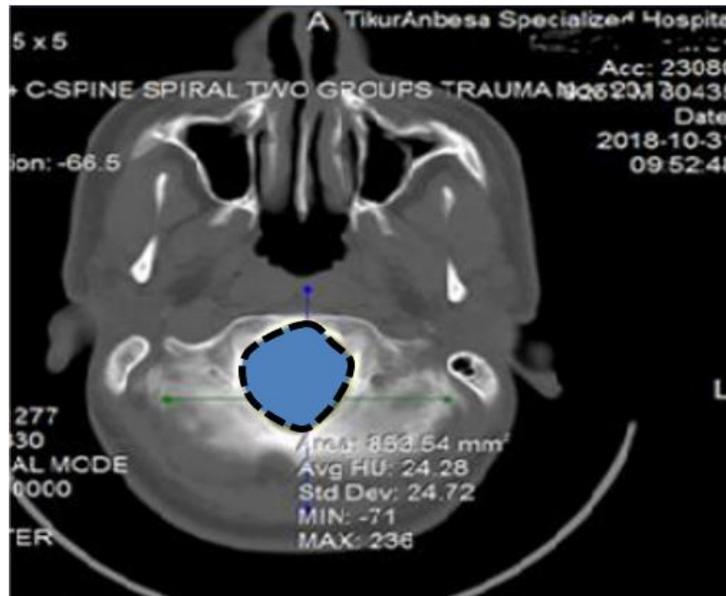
Square dot line indicating outline of the Area of FM on skull CT scanned images at Tikur Anbessa Specialized Hospital, Addis Ababa.
